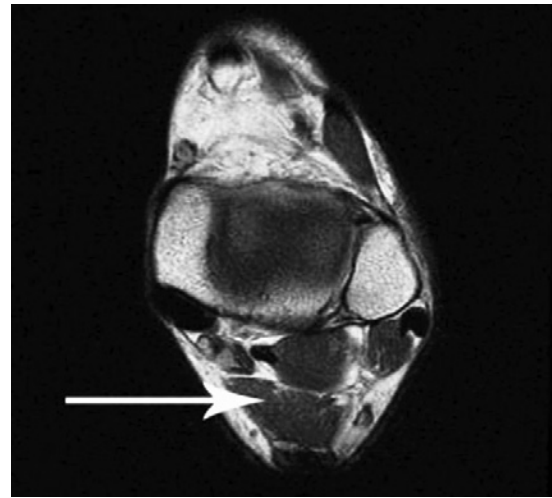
Accessory soleus muscle inserted in MRI axial plane (white arrow)
